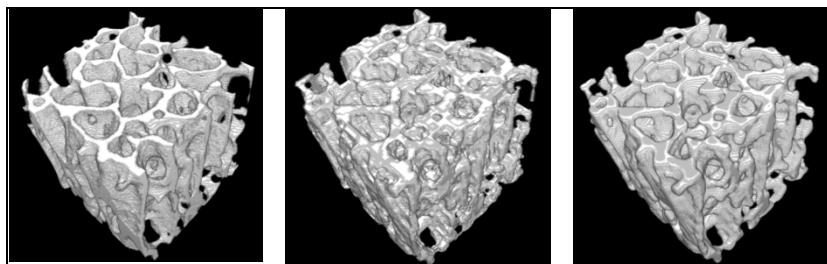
3D renderings of HR- μ CT (left), sv-MR thresholds at 70% BVF (middle) and sinc-MR thresholds at 70% BVF (right). The SMIs are 0.535, 0.504 and 0.662 respectively.
